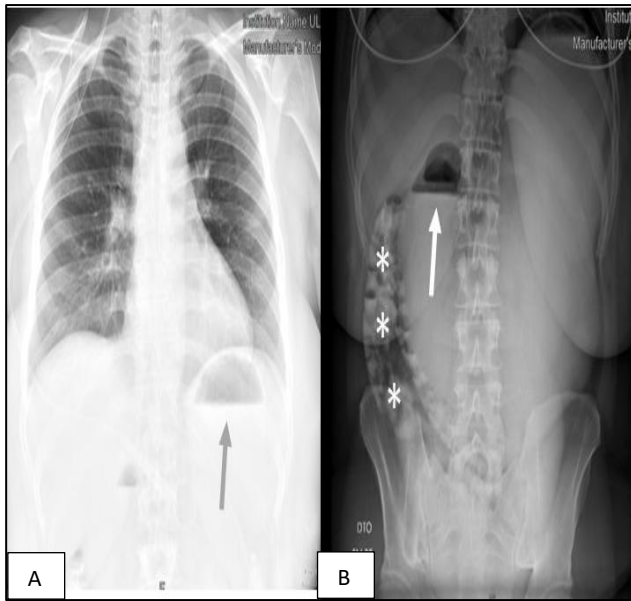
(A and B): Thoracic and abdominal x-rays showing air-fluid levels of stomach and small intestine (arrows) and oral contrast in the colon (*).
